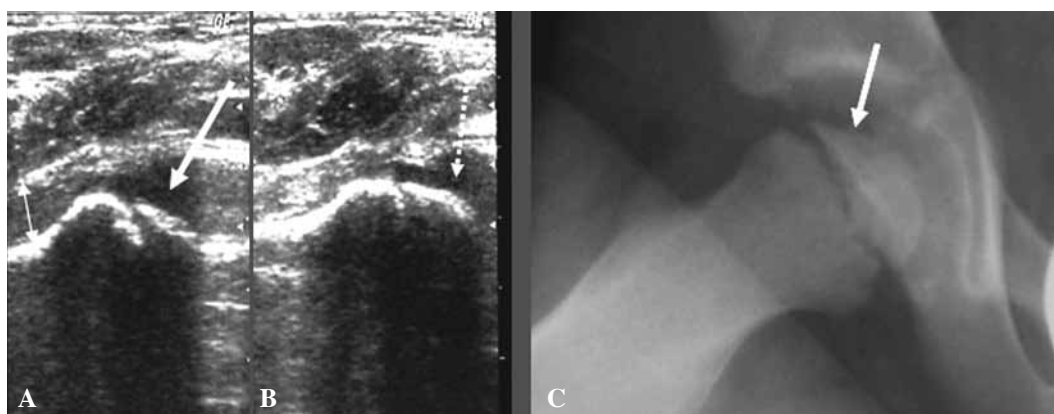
Sonographic images of both hips and plain radiograph of the right hip of a 6½-year-old child who presented with right hip pain. A : Ultrasound scan demonstrated abnormal contour of the right femoral head (thick arrow) and convex bulging of the joint capsule due to the presence of a moderate-size anechogenic effusion (small double arrow). The diagnosis of Perthes' disease was made. B : Sonography of the left hip showed no effusion and normal morphology of the femoral head (dotted arrow). C : Plain radiograph of the right hip revealed the flattening of the femoral head (arrow) confirming the diagnosis.
